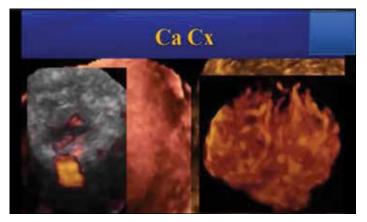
3D- USG with color doppler in cervical carcinoma
